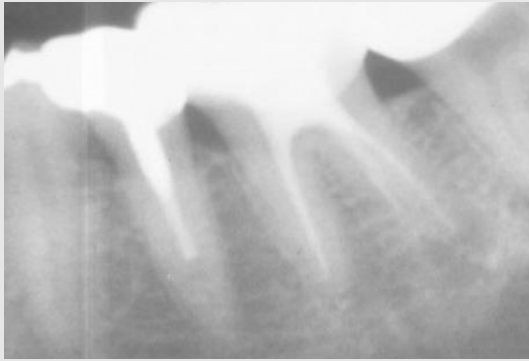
Success case: pre-op periapical view.
